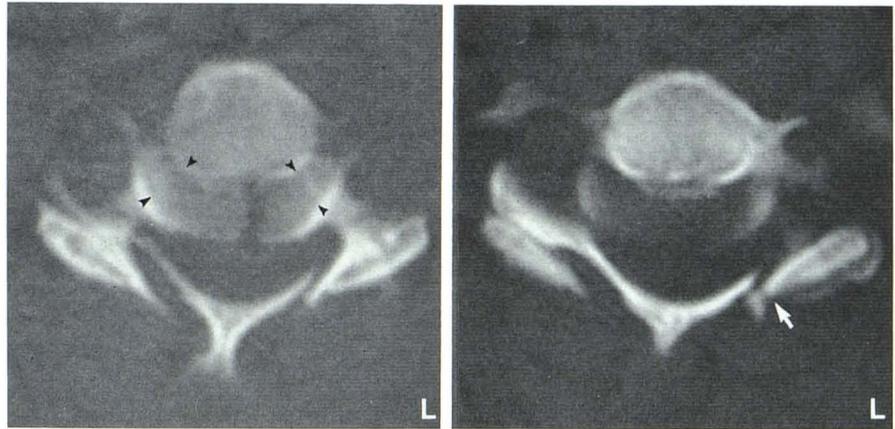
Contiguous CT sections in case with locked facet and fractured articular pillar on right. Fracture lines in articular pillar (*arrow*), abnormally aligned superior (S) and inferior (I) articular facets, and distracted uncovertebral joint (*arrowheads*).
